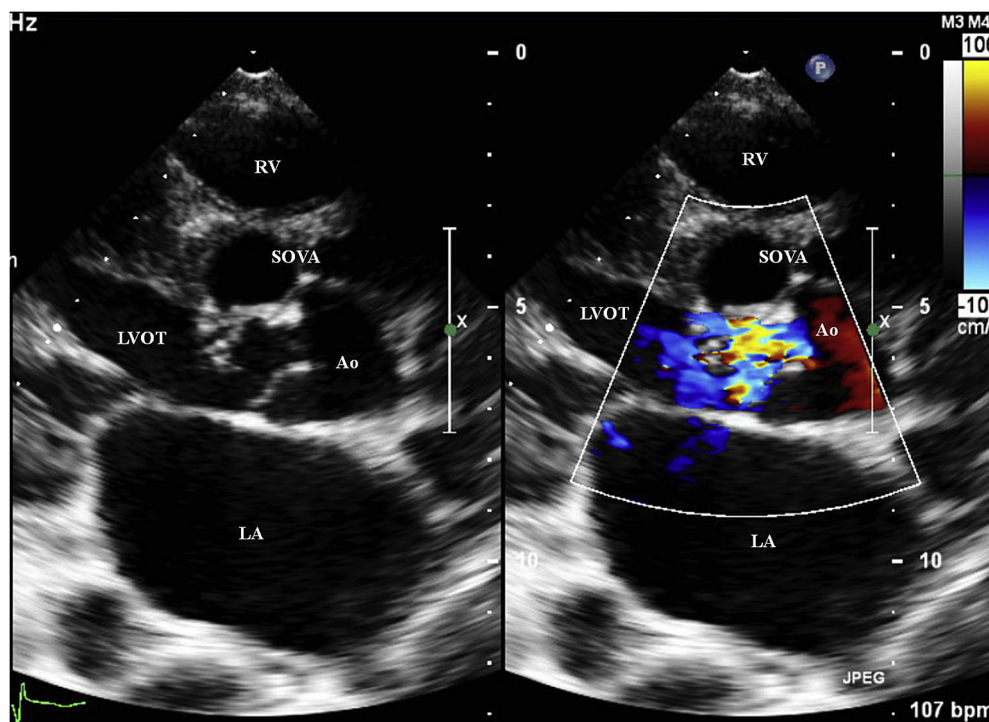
Transthoracic echocardiography unruptured sinus of valsalva aneurysm and aortic regurgitation. LA – left atrium, LVOT – left ventricular outflow tract, RV – right ventricle, Ao – aorta, SOVA – sinus of valsalva aneurysm.
